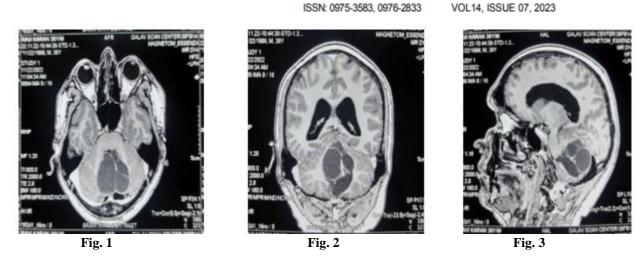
MRI contrast images depicting axial, coronal, and sagittal cuts of a 36-year-old male patient with a posterior fossa hemangioblastoma.
